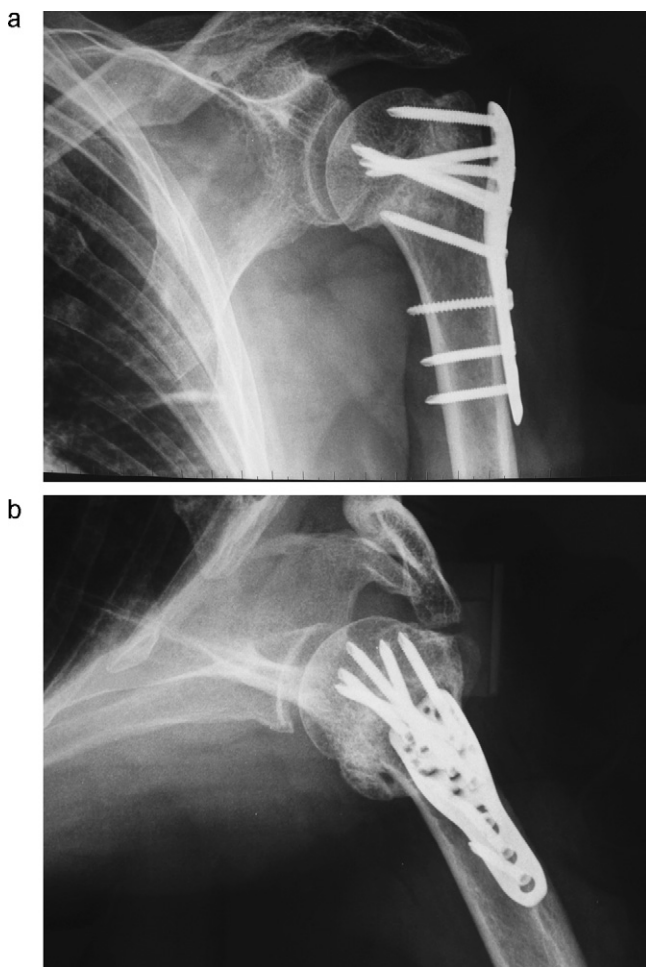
(a) AP X-ray of three-part fracture treated with Philos plate (18 months post-op). (b) Lateral X-ray of three-part fracture treated with Philos plate (18 months post-op).
